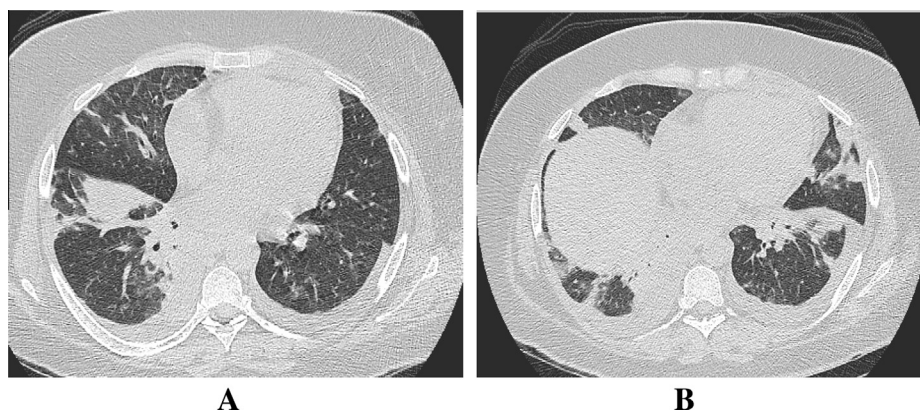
HRCT scan (A and B) showing bilateral multiple infiltrates of ACS as well as bilateral pleural effusion.
